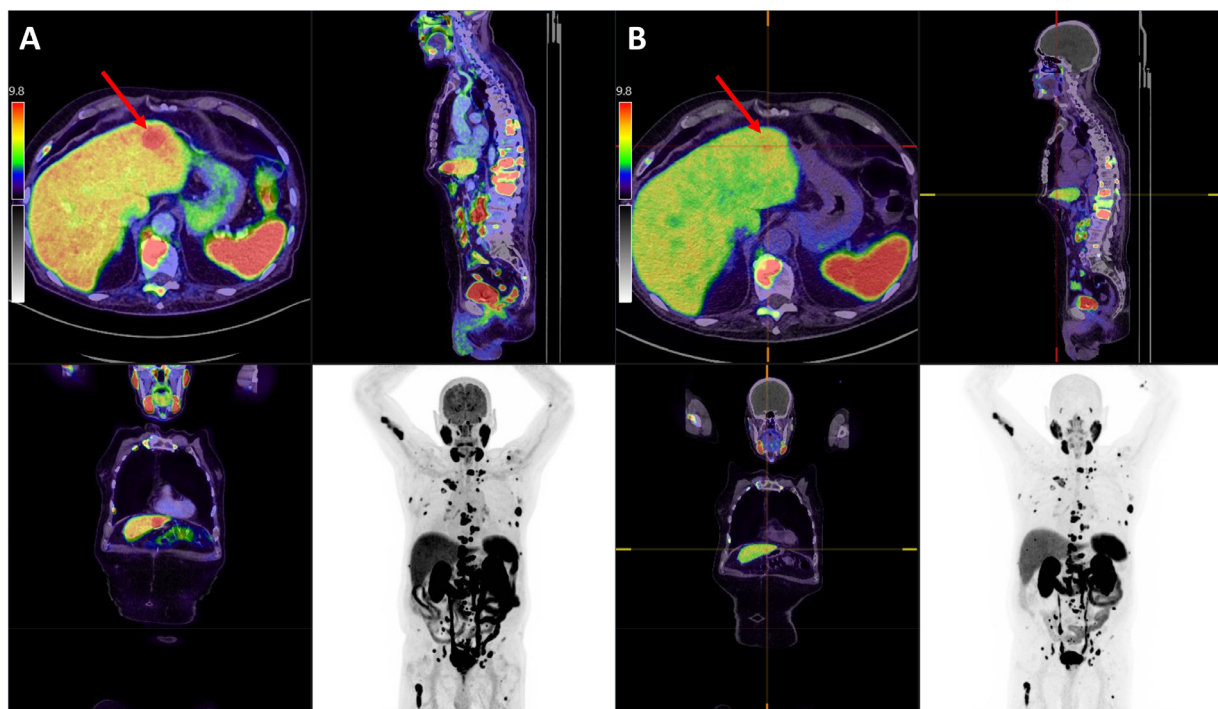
Example of a patient who was referred for PSMA-RLT. In the dual scan with FDG (A) and 18F-PSMA (B), a liver metastases presented FDG-positive but PSMA-negative (red arrows).
